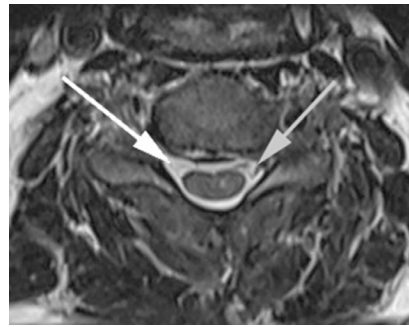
MRI of the C5 root showing the avulsion with no visible anterior and posterior part of the root (white arrow) compared to contralateral side (grey arrow). The same image is present concerning the C6 root.
